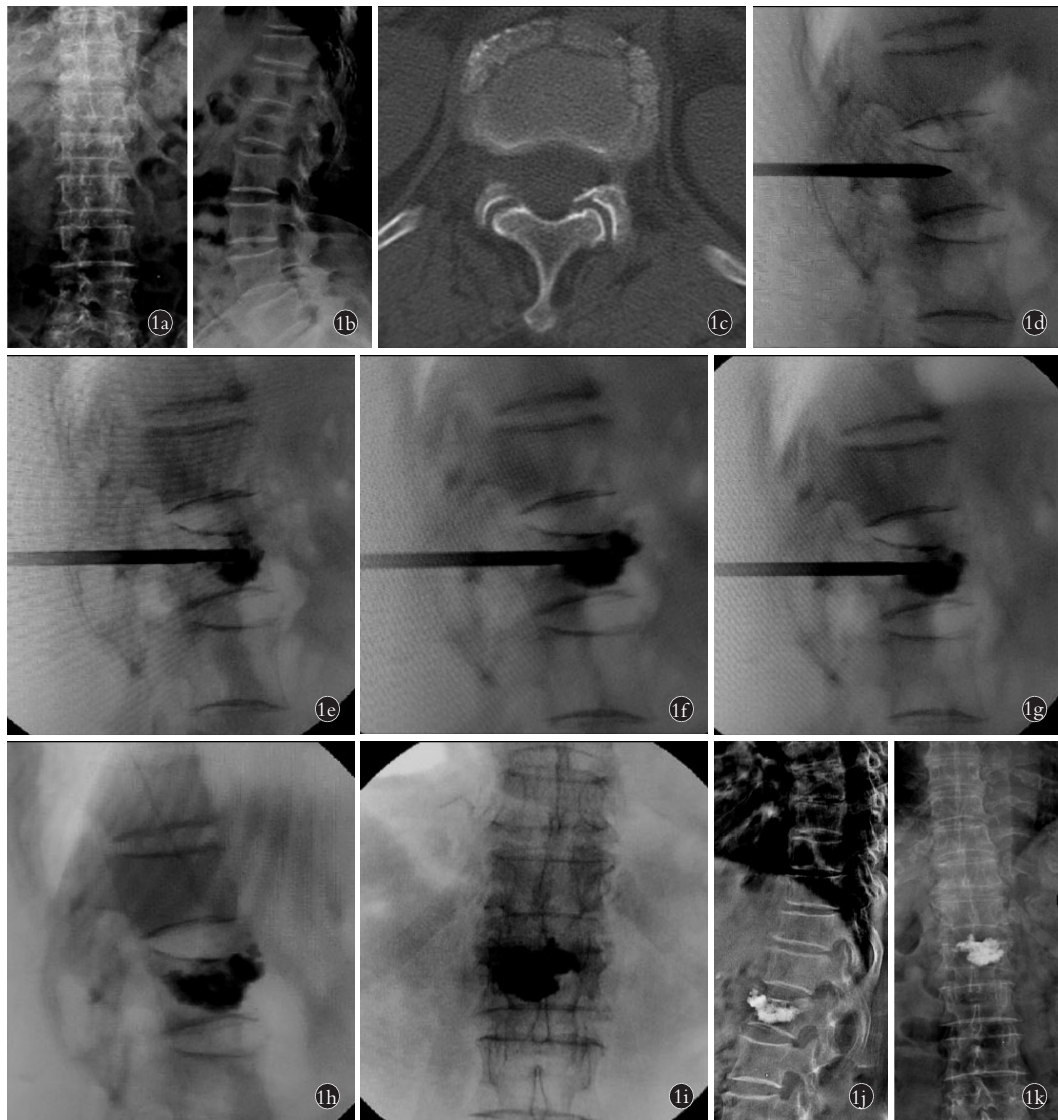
患者,女,81 岁。摔倒致腰背部疼痛 3 h 余 1a,1b. 术前腰椎正侧位 DR 检查,L₁ 椎体稍变扁,椎体上缘骨质稍凹陷。考虑 L₁ 椎体压缩性骨折 1c. 术前腰椎椎体平扫 CT 检查,L₁ 椎体稍变扁,椎体骨质不连续,考虑 L₁ 椎体压缩性骨折 1d. PVP 术中骨水泥注射过程中,穿刺针进入椎体位置 1e,1f,1g. 按骨水泥注射顺序排序的椎体情况 1h,1i. 骨水泥注射完成后的椎体情况 1j,1k. 术后腰椎正侧位 DR 检查示 L₁ 椎体骨折术后,L₁ 椎体稍变扁,其内可见骨水泥影
